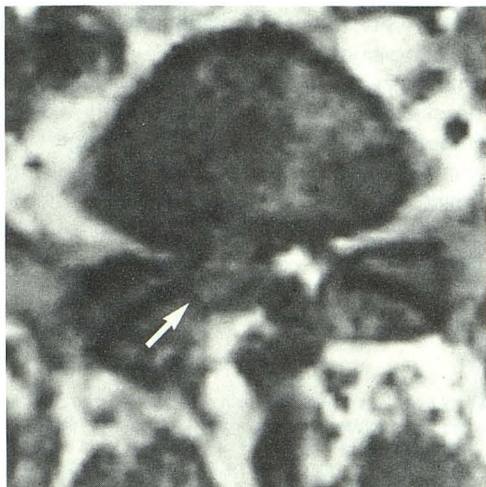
Recurrent disk herniation in 30-year-old woman 2 years after right L5–S1 discectomy. Axial T1-weighted image at low L5 level shows large focal polypoid disk protrusion (arrow) beyond posterior margin of vertebral body to the right of midline. Mass fills right lateral recess and displaces and compresses hypointense thecal sac.
